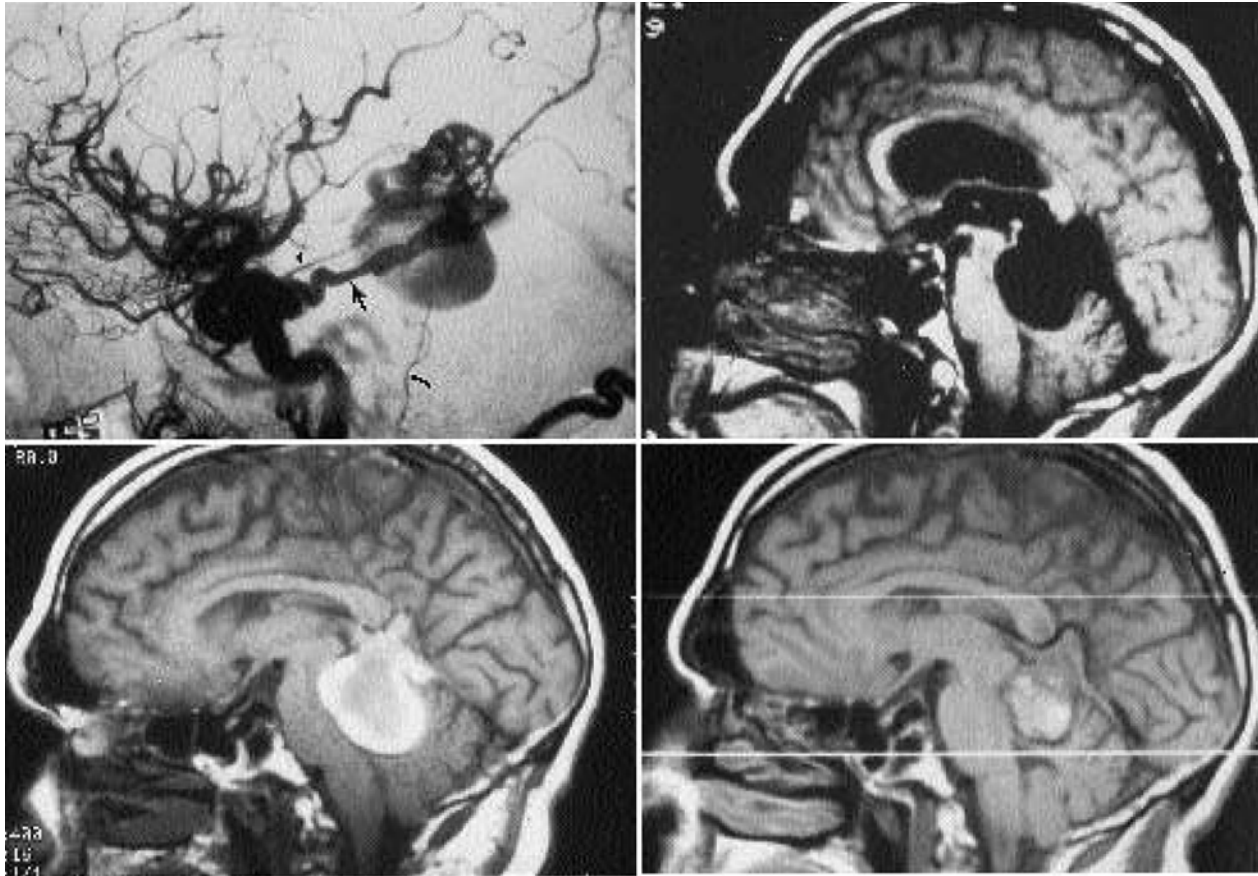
Angiographic and magnetic resonance (MR) imaging studies of the dural arteriovenous malformation (AVM) presenting in Case 3. *Upper Left:* Lateral right internal carotid angiogram showing a dilated tentorial artery (*large arrow*), middle meningeal artery (*arrowhead*), and occipital artery (*small arrow*) feeding a plexiform nidus that drained through a dilated vein of Galen aneurysm. The straight sinus is thrombosed. *Upper Right:* A T₁-weighted sagittal MR image performed before embolization and radiosurgery showing the flow void within the nidus and the aneurysm. There is moderate obstructive hydrocephalus. *Lower Left:* Magnetic resonance image demonstrating that the dural AVM and vein of Galen aneurysm are completely thrombosed after two embolization procedures and radiosurgery with 1700 cGy. The patient recovered rapidly from symptoms of brainstem compression. *Lower Right:* Follow-up sagittal MR image 1 year later showing the vein of Galen aneurysm to be smaller with less mass effect exists on the brain stem compared with the previous study. Note that the lateral and third ventricles are small after ventriculoperitoneal shunting.
